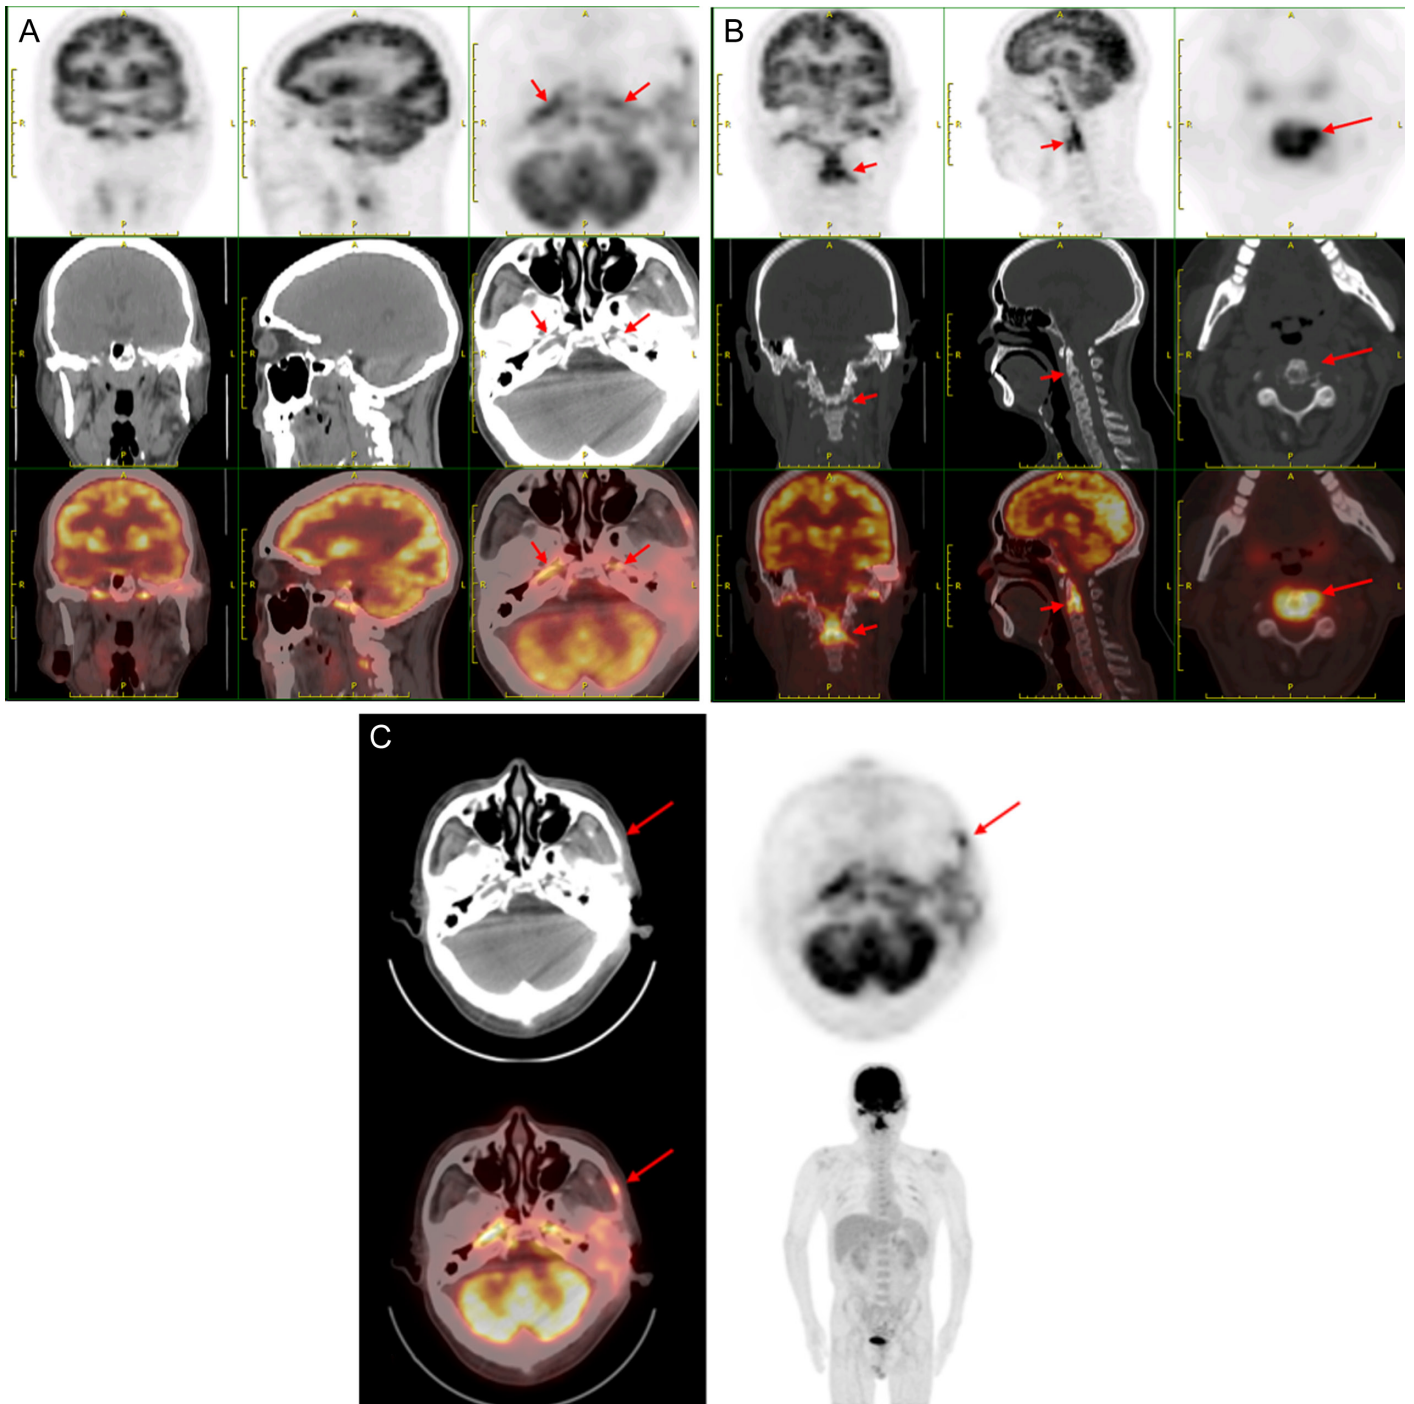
A-C. Positron emission tomography-computed tomography of the patient in case 1. The left zygomatic bone, bilateral temporal bones, part of the skull base, C2, and C3 showed dot-like foci with increased fluoro-2-deoxy-D-glucose uptake (SUVmax: 8.1), and the bilateral distribution was basically symmetrical. The corresponding parts of the computed tomography showed local cortical defects and soft tissue swelling.
